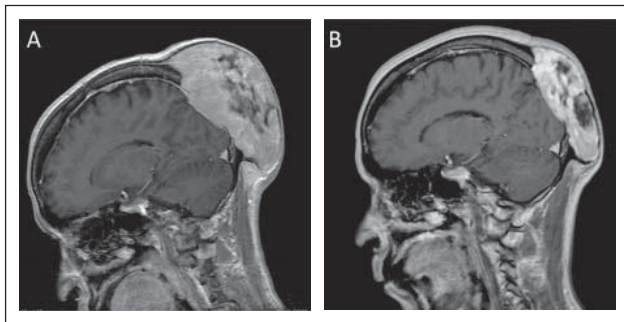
T1-weighted, gadolinium-enhanced sagittal MR images of a 57-year-old woman with calvarial metastasis from thyroid cancer. (a) Pre- and (b) 3 months post-irradiation 40 Gy per 20 fractions.
